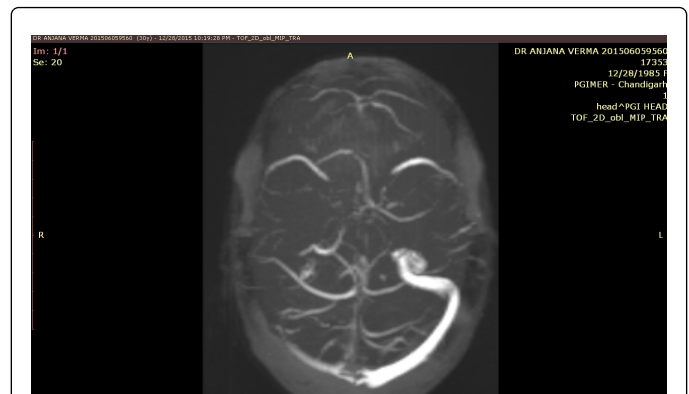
(MRI Transverse)-MRI Angiogram in transverse plane showing right transverse sinus thrombosis.
